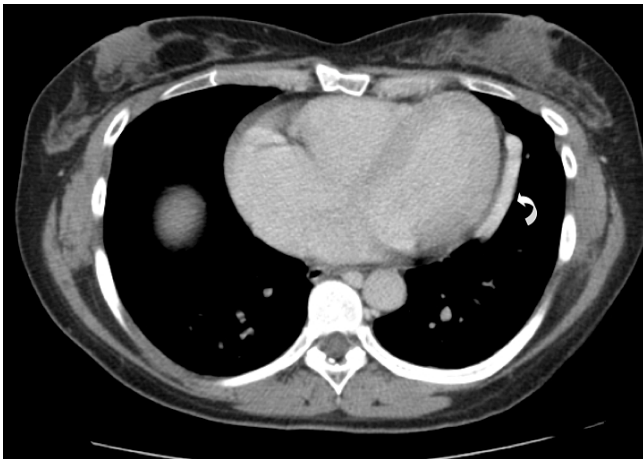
Axial CT image obtained after intravenous (IV) contrast injection demonstrated a large enhancing paracardiac varix (curved arrow) correlating with the radiographically seen opacity
